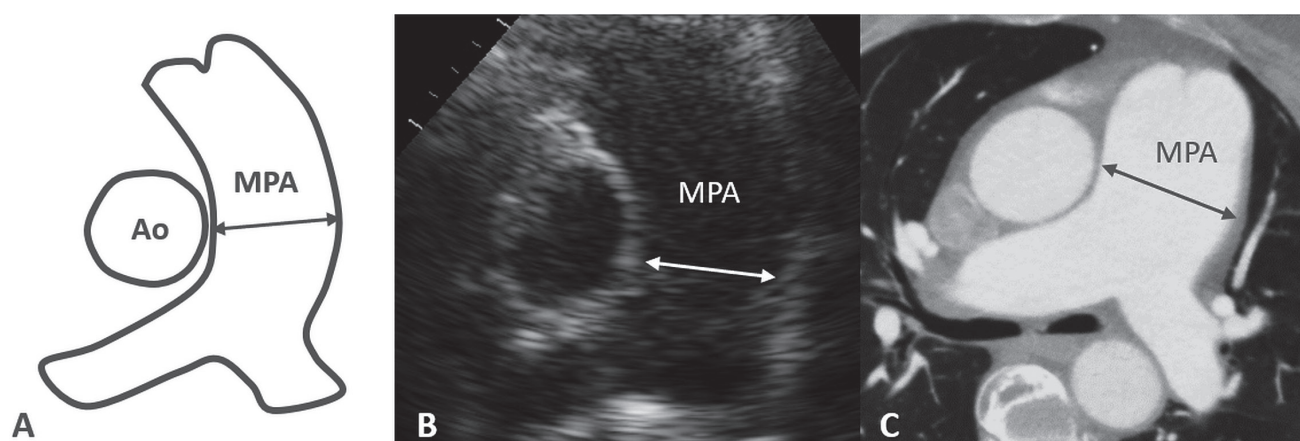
Pulmonary artery measurement: A. scheme; B. by echocardiography; C. by computer tomography
